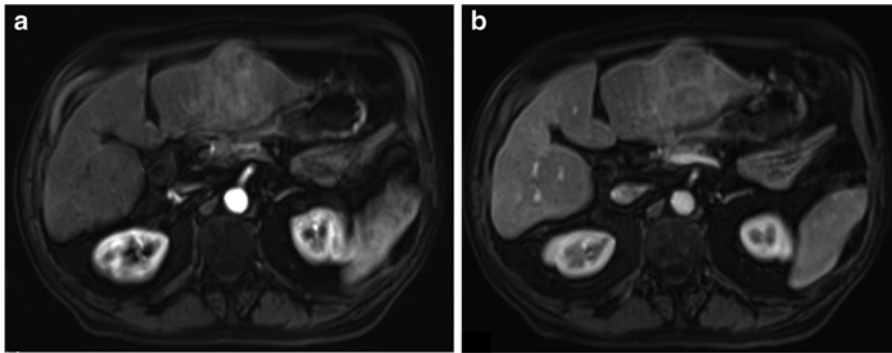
MRI appearance of an HCC lesion in the left liver lobe demonstrating characteristic enhancement in the early arterial phase (a), with subsequent contrast washout in the delayed, portal venous phase (b)
